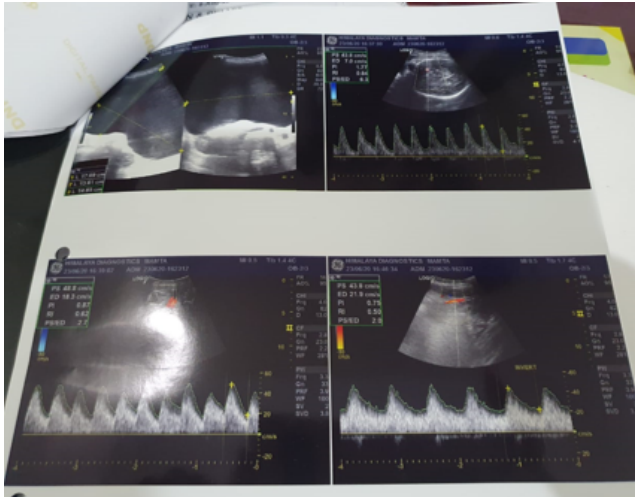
USG for fetal well being showing normal color Doppler study.
